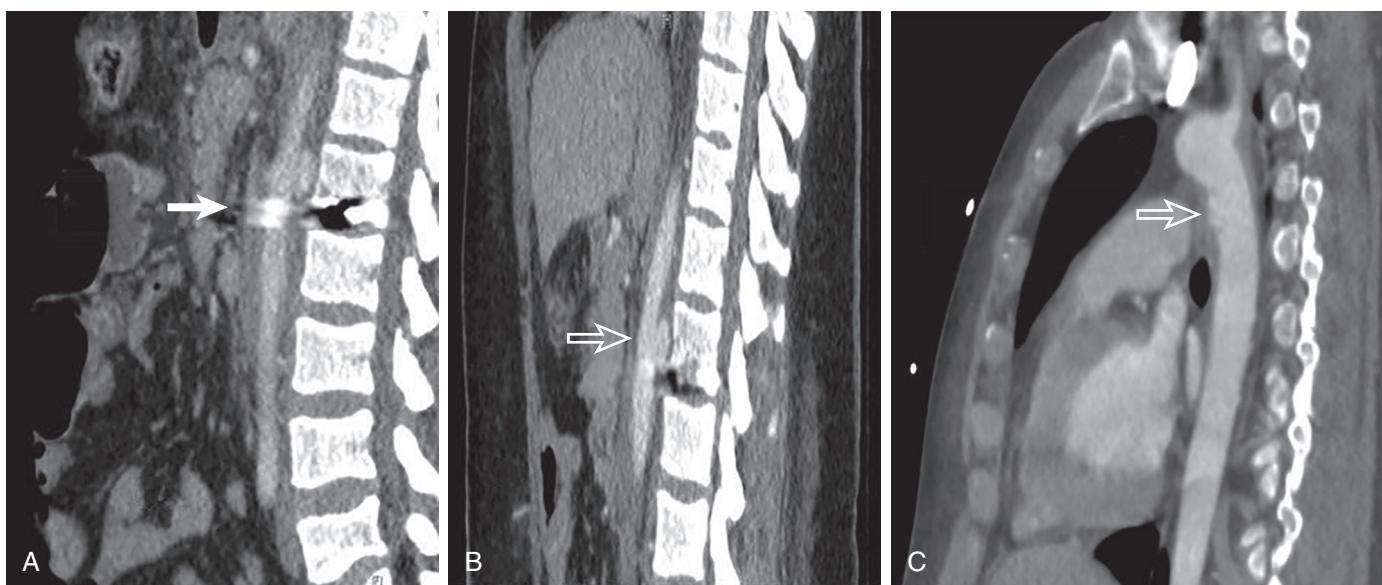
Utilization of CTA in Detecting Arterial Truncal Injuries. (A,B) CTA of a 17-year-old male shot through the abdomen. The solid arrow points to bullet trajectory whereas the open arrow points to an aortic pseudoaneurysm due to heat/blast injury. (This was not appreciated during abdominal exploration.) (C) Thoracic aorta injury (arrow) distal to the left subclavian artery in a 10-year-old male involved in a motor vehicle accident.
